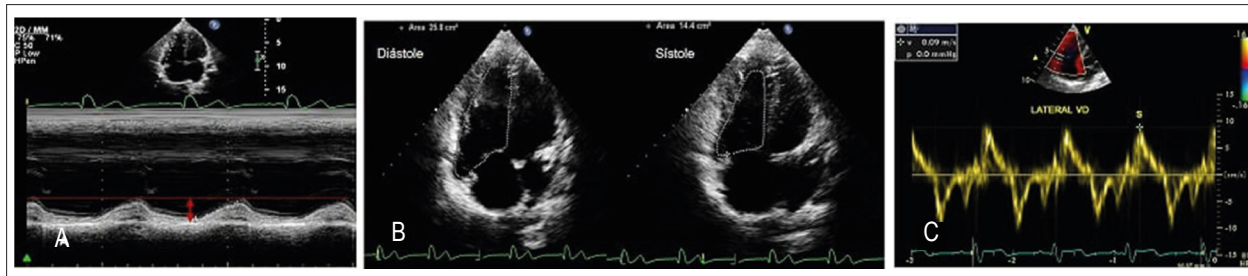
Conventional parameters for assessing right ventricle systolic function. (A) Tricuspid annular plane systolic excursion (TAPSE). (B) Fractional area change (FAC) registered by the difference between the end-diastolic and end-systolic areas/end-diastolic area. (C) Spectral curve obtained by tissue Doppler analysis at the level of the tricuspid valve ring. Peak myocardial wave velocity during systole (S). RV = right ventricle.
